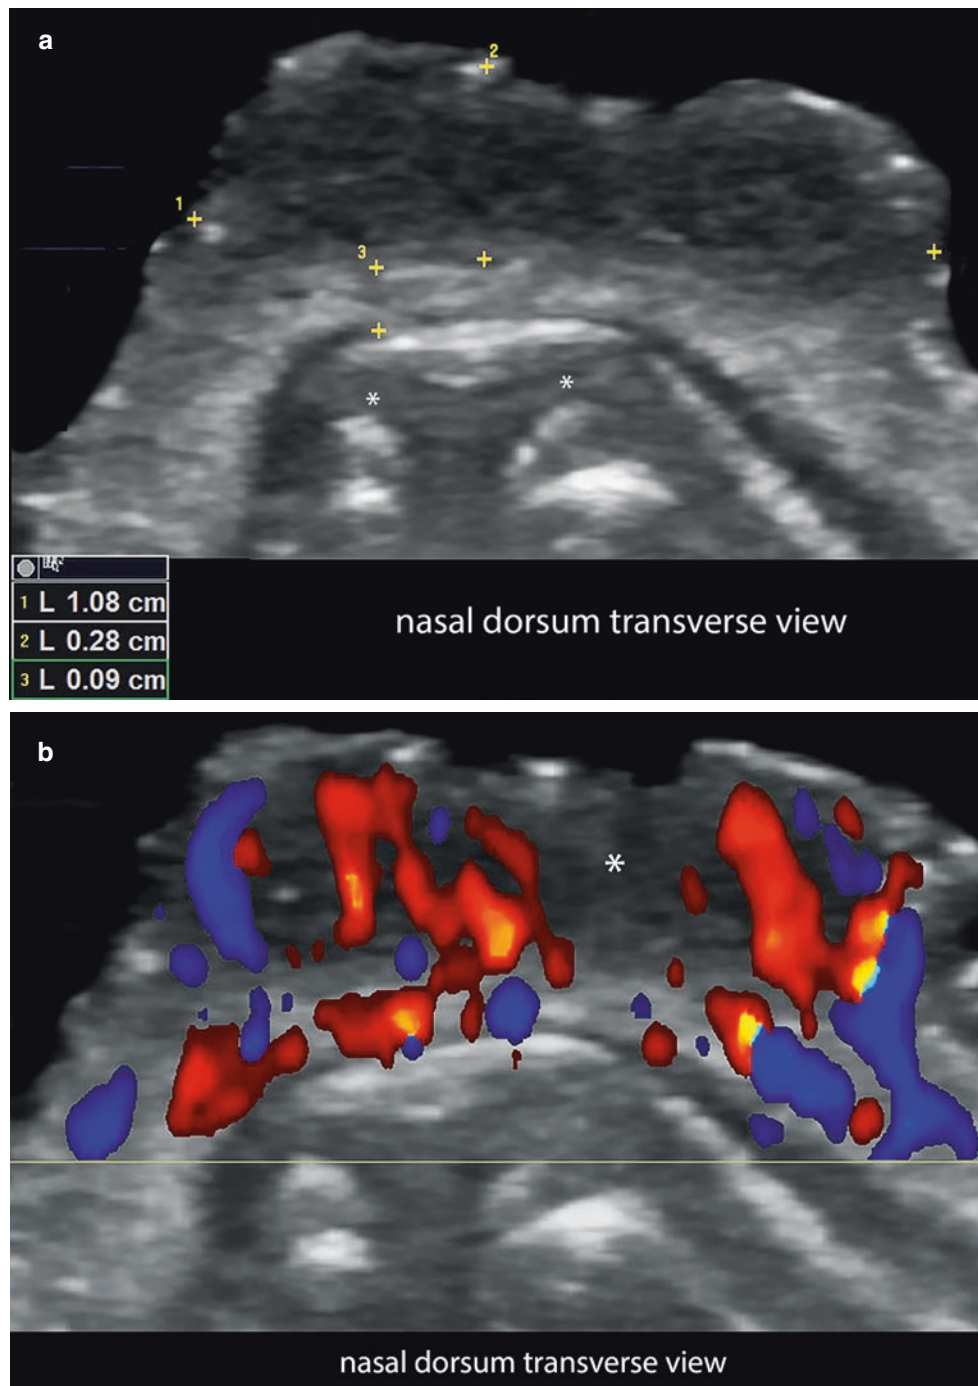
Squamous cell carcinoma of the nasal region. (a) Greyscale; and (b), color Doppler ultrasound (nasal dorsum; transverse view) demonstrate 1.0-cm (transverse) \times 0.3-cm (thickness), ill-defined, hypoechoic lesion (between markers). The deep part of the lesion is
